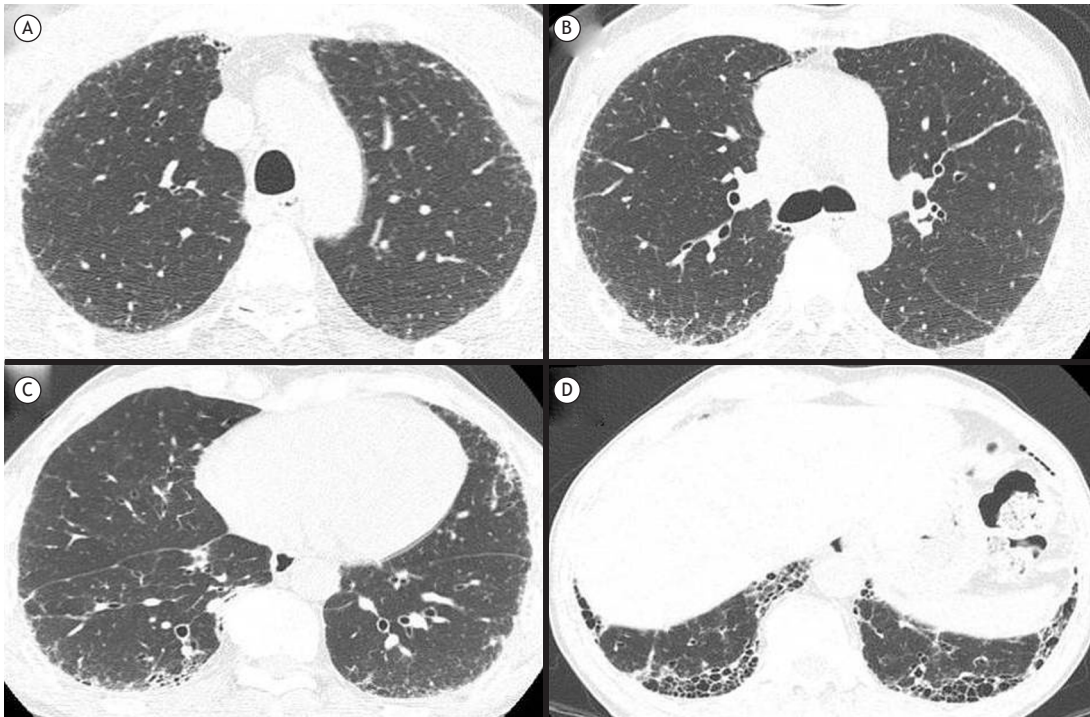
Chest HRCT scans showing findings consistent with the pattern of usual interstitial pneumonia: A) discrete subpleural reticular opacities in the upper lobes; B) subpleural reticular opacities and discrete areas of ground-glass abnormalities at the level of the carina; C) peripheral reticular opacities, traction bronchiolectasis, and discrete areas of ground-glass abnormalities predominantly in the lower lobes; and D) peripheral honeycombing and traction bronchiolectasis in the lower lobes.
